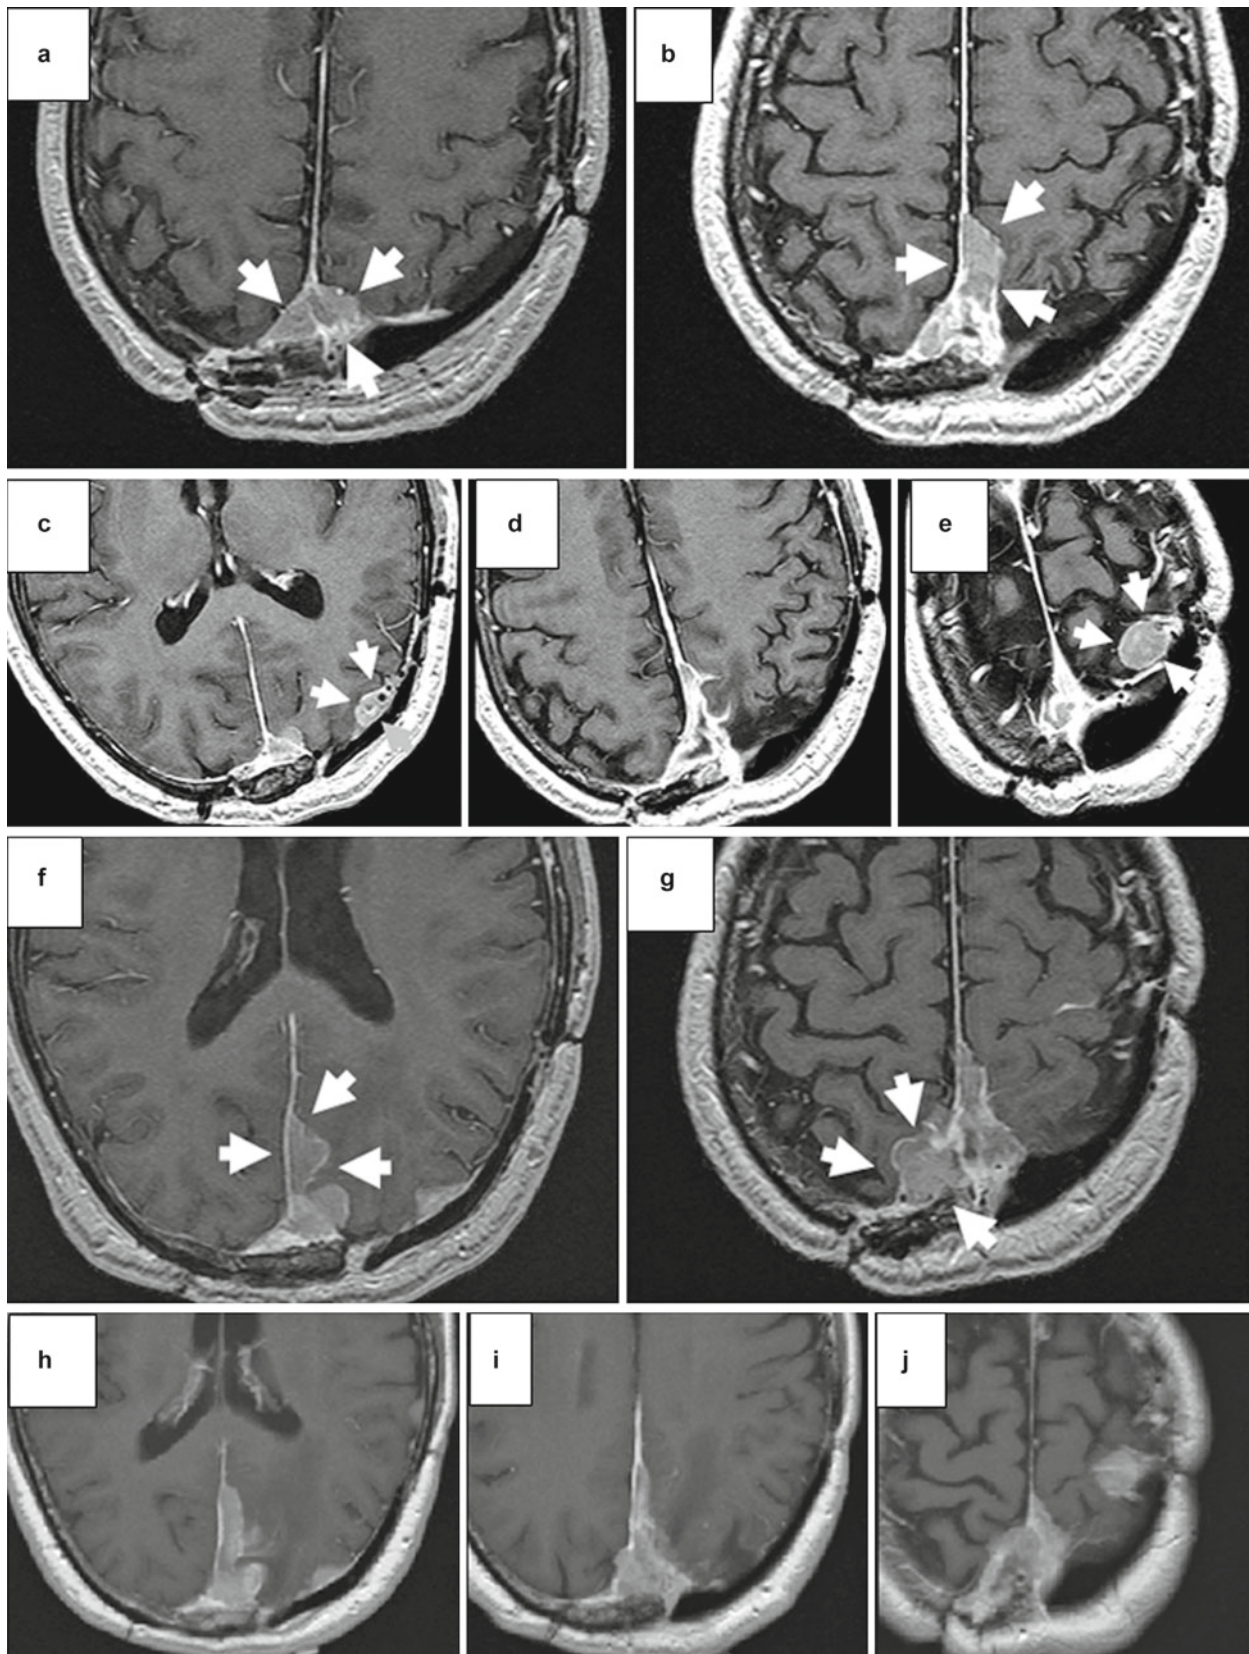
Axial postcontrast magnetic resonance imaging (MRI) of an atypical meningioma in a 67-year-old man. (a) The first GKS was performed for residual tumor after the initial surgical resection (*arrows*). (b) The second GKS was performed 3 years later to treat regrowth of the anterosuperior portion of the tumor (*arrows*). (c–e) The third GKS was performed 1.5 years after the second GKS to address two newly developed distant tumors (*arrows*) in the occipital (c) and parietal
